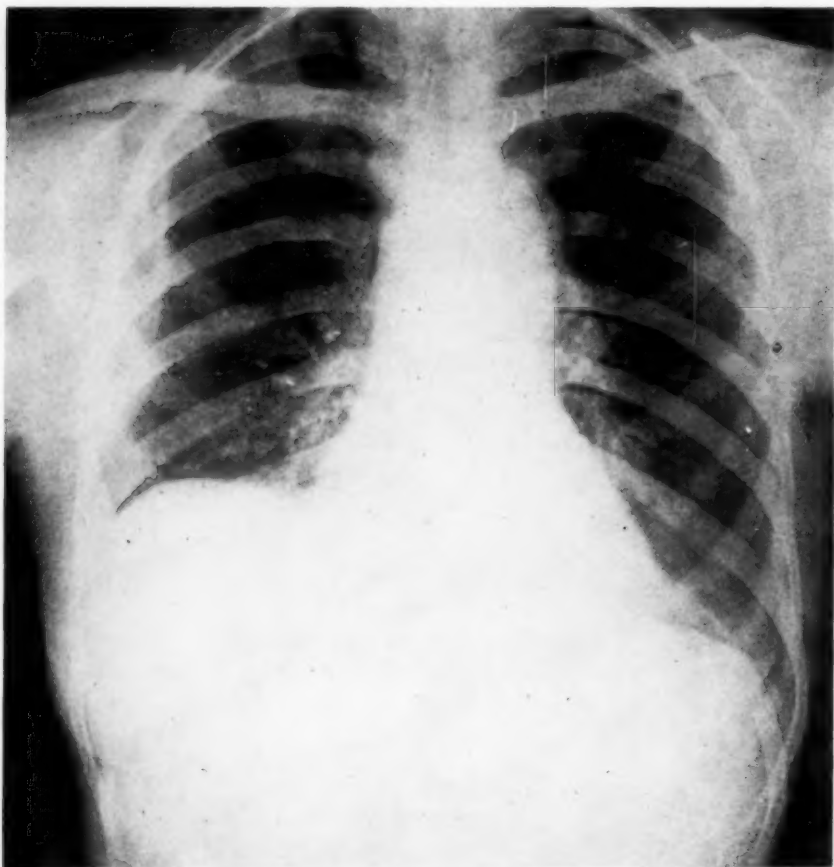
Roentgenogram of chest two months postoperatively.
